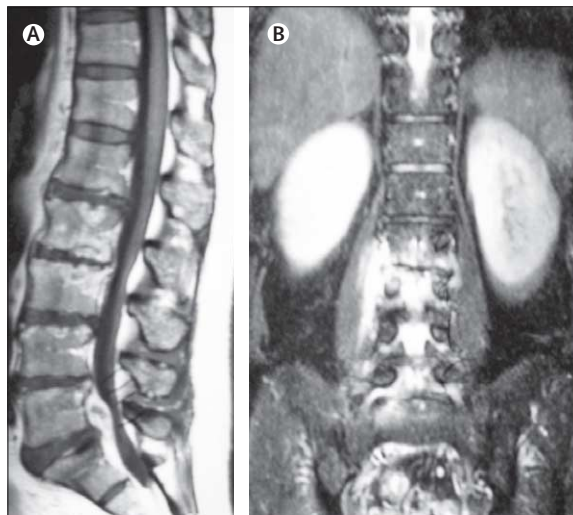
Magnetic resonance imaging (MRI) has become a powerful aid in investigating bone and soft-tissue lesions in brucellosis patients (A) T1 and (B) T2-weighted MRI images of a 63-year-old male with spinal osteomyelitis, sacroiliitis, and psoas abscess caused by brucella infection.
